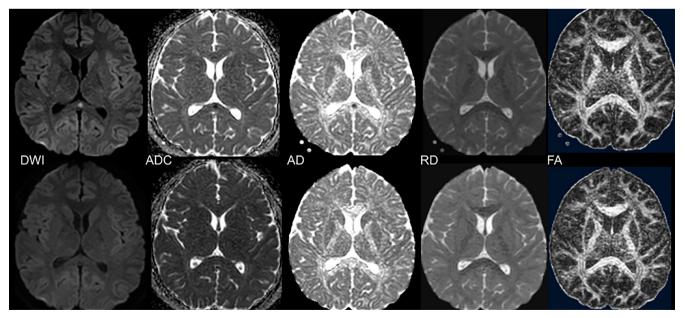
Upper row: In the DTI image at the time of admission, the splenial lesion has a definite high signal on the DWI, and the reduction of ADC and AD is visible at first glance. The decrease in RD is not apparent, and the change in FA is less noticeable. Bottom row: Follow-up DTI image revealed resolution of diffusion abnormality.
